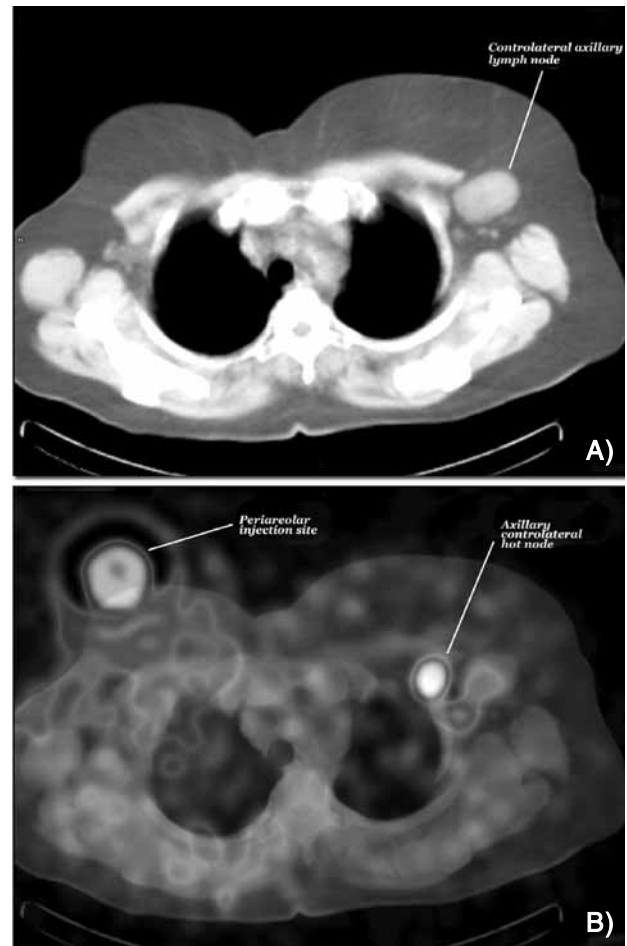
Axillary transaxial SPECT-CT lymphoscintigraphy. Same slice of axillary node in CT (A) and SPECT fused with CT (B), 2 h after injection of 1 mCi ^{99m}Tc nanocolloids in the periareolar breast.
